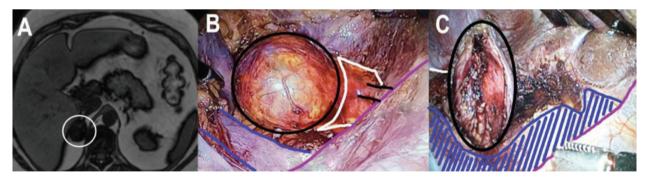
Preoperative diagnostic magnetic resonance imaging, photographs of intraoperative anatomic relations and adrenal gland after partial adrenalectomy for right-sided adrenal tumor.
